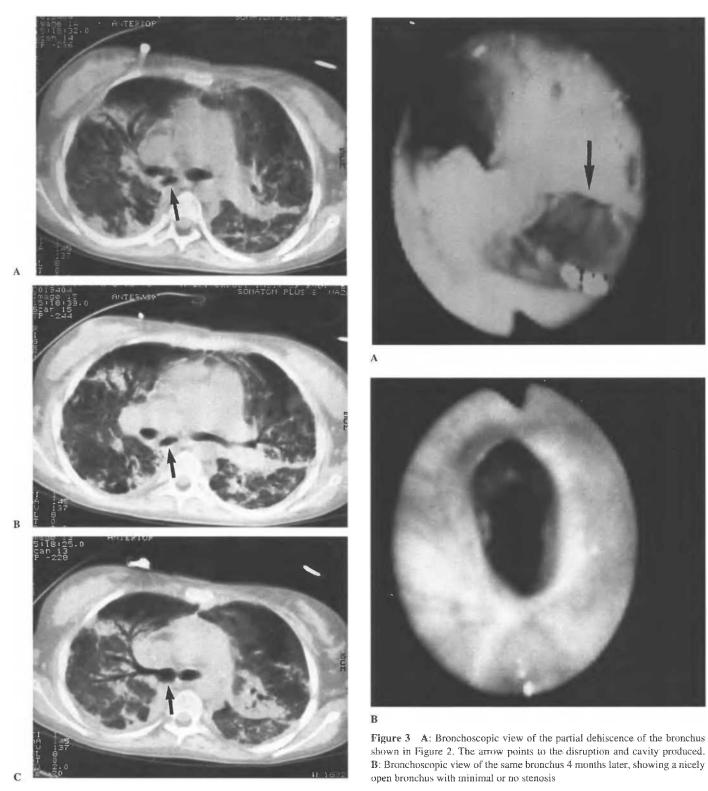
This CT scan of a patient was taken 4 weeks following lung transplantation for cystic fibrosis. A,B: Note the presence of air on the right posterior to the bronchus (arrow). There is also significant pulmonary parenchymal disease in this view. C: Following the CT scan further inferiorly, it can be easily noted that there is partial disruption at the area of the anastomosis; the two ends are held together somewhat tenuously
